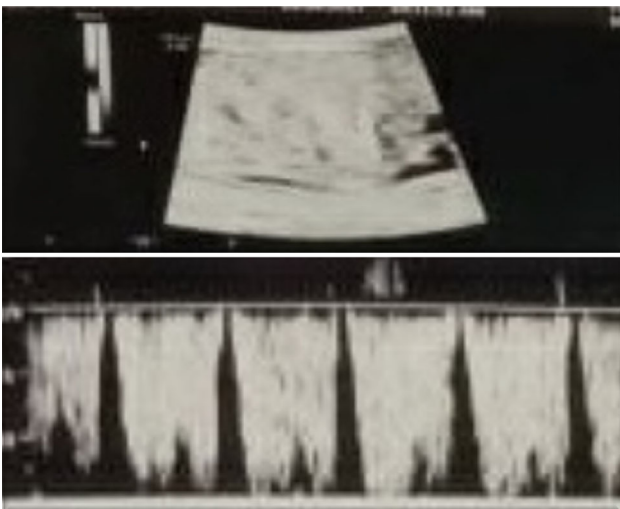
Scan image of Ductus Venosus Dopplers
